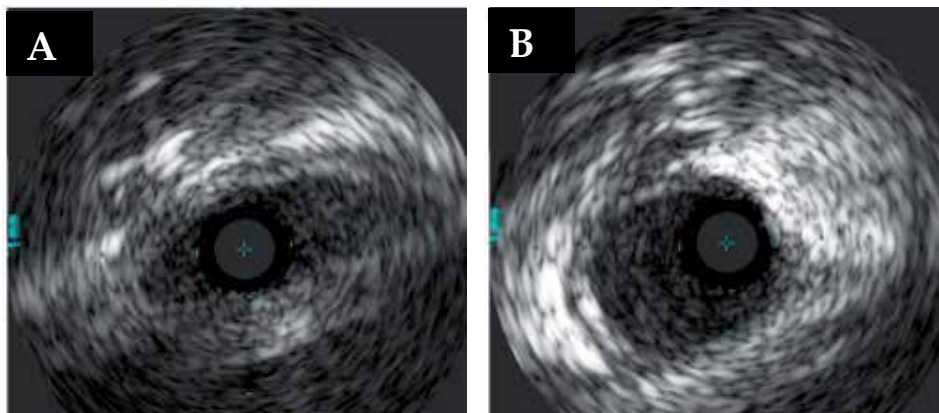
Intravascular ultrasound images showing the intramural segment (A) and the extramural segment (B) of an ectopic right coronary artery connected with the left sinus.
